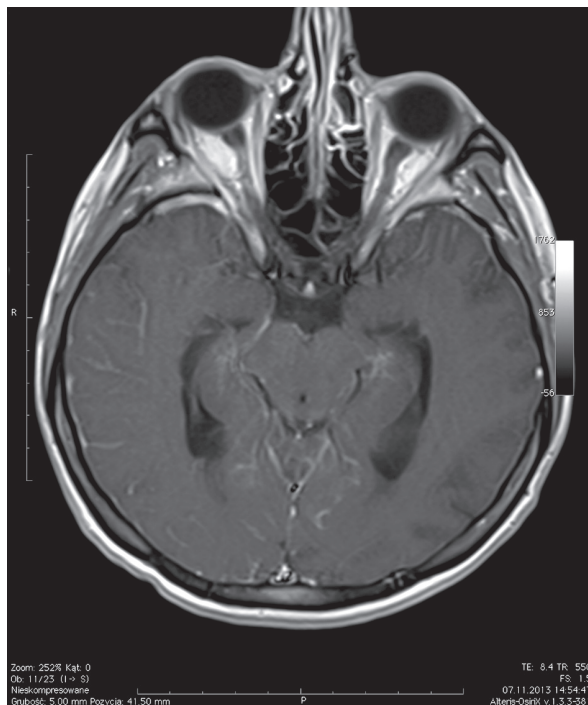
MRI of the patient with CNS involvement in the course of PTLD – segmental, asymmetrical thickening of the meninges. Courtesy of dr Dariusz Poplawski, Department of Radiology, Poznan University of Medical Sciences
